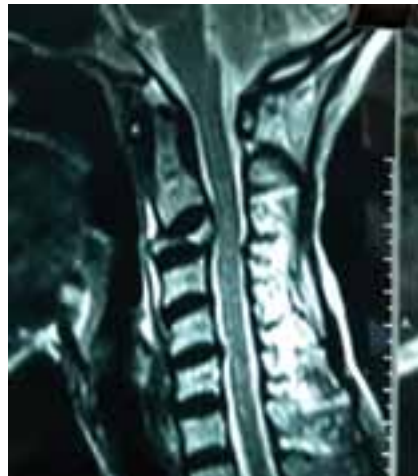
MRI of cervical spine showing collapsed 3rd cervical vertebra with mild cord compression
